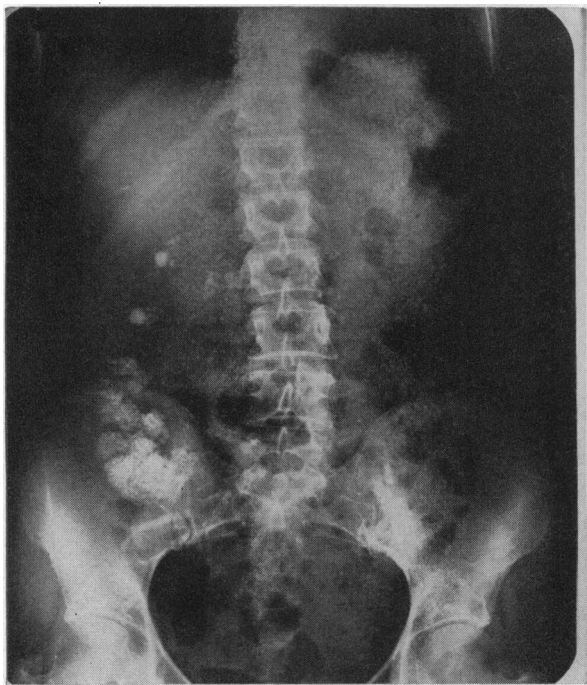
(Case 3).—Kidney-ureter-bladder x-ray film taken after one year. No recurrence of calculi is noted.
